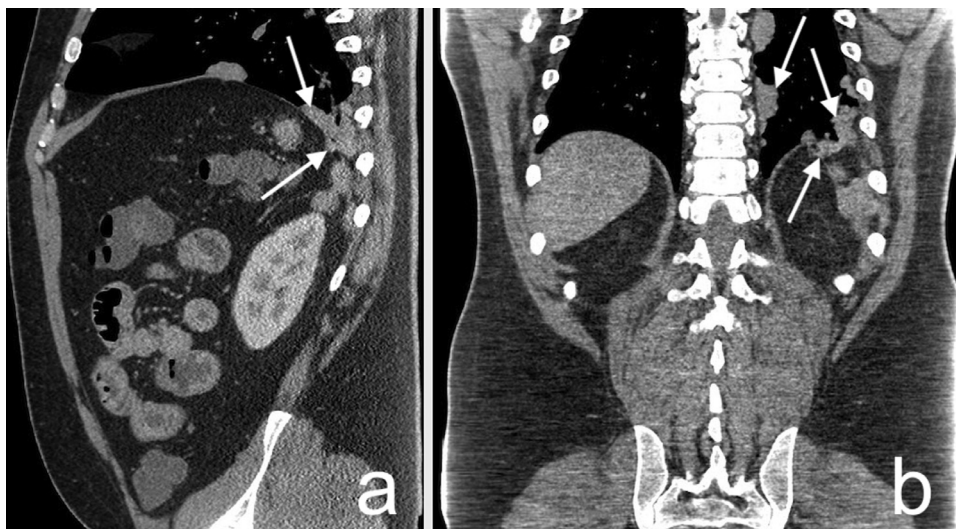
CT enhanced images. (a) Sagittal and (b) coronal projections demonstrating splenosis (arrows) on both sides of the diaphragm.
